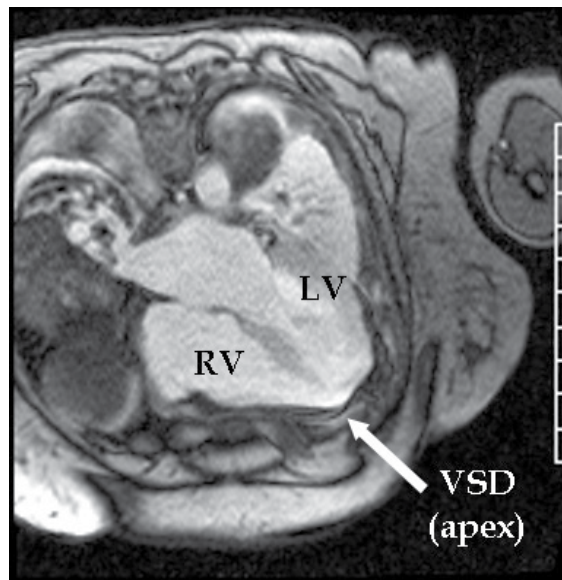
Cardiac MRI demonstrating an apical defect. Gated cine images indicated a left to right shunt in which quantitative assessment can be used to calculate the shunt fraction and size of the defect.
